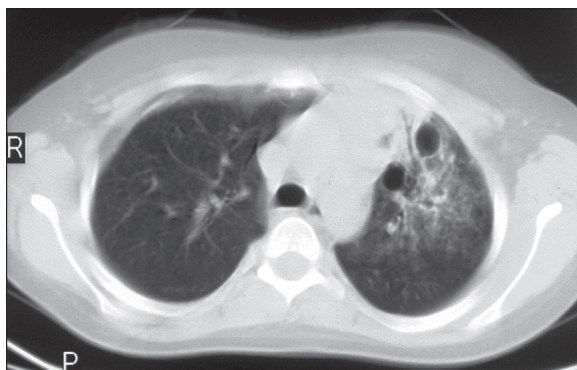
Axial CT scan of the chest, pulmonary window. Parenchymal and atelectatic consolidations with air bronchogram, cavities in the upper lobe of left lung.
